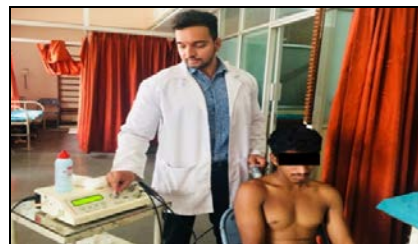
Subject Receiving Ultrasound Therapy
